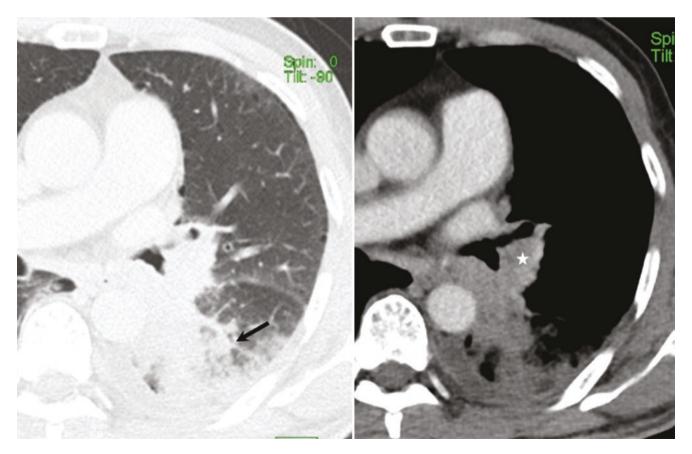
A 65-year-old man with bronchial carcinoma. Contrast-enhanced axial CT image in lung and soft tissue window shows a focal area of post-obstructive atelectasis (arrow) secondary to a central mass (asterisk)
